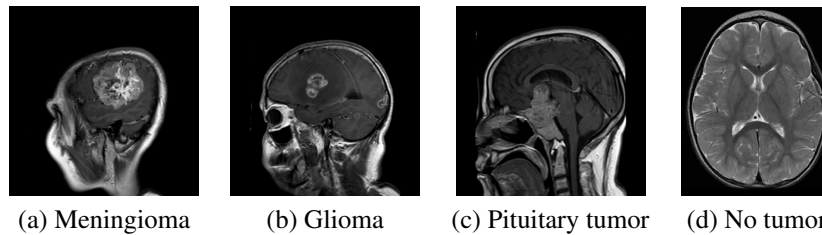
Sample of sagittal MRI from the dataset: (a) Meningioma, (b) Glioma, (c) Pituitary tumor, (d) No tumor.
